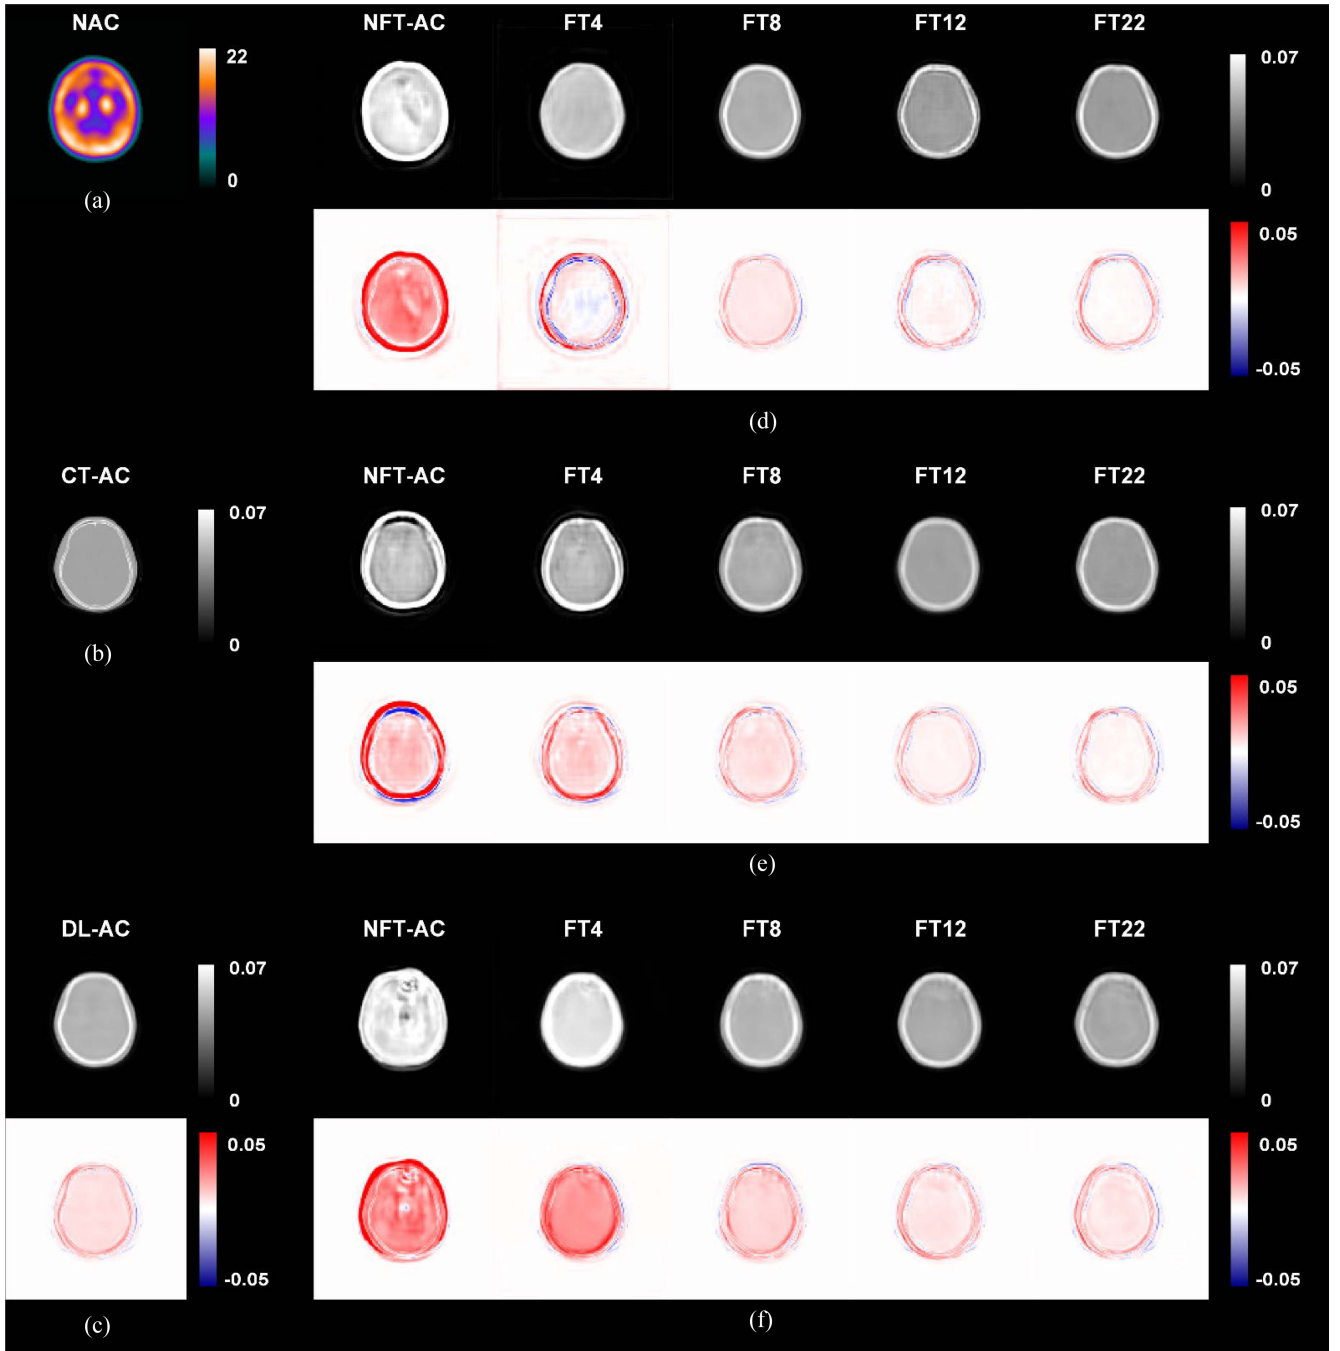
Representative results of an 80-year-old female patient. Sample axial (a) NAC SPECT image and  $\mu$ -maps images of (b) CT-AC, (c) DL-AC, NFT-AC, and FT-AC methods with different numbers of FT data for the tested S-TRODAT-1 data using (d) S-ECD (cross-tracer), (e) G-TRODAT-1 (cross-scanner), and (f) G-ECD (cross-tracer+cross-scanner) as the pretrained network. The corresponding error map as compared to CT-AC is shown under each DL-generated  $\mu$ -map image, respectively.
